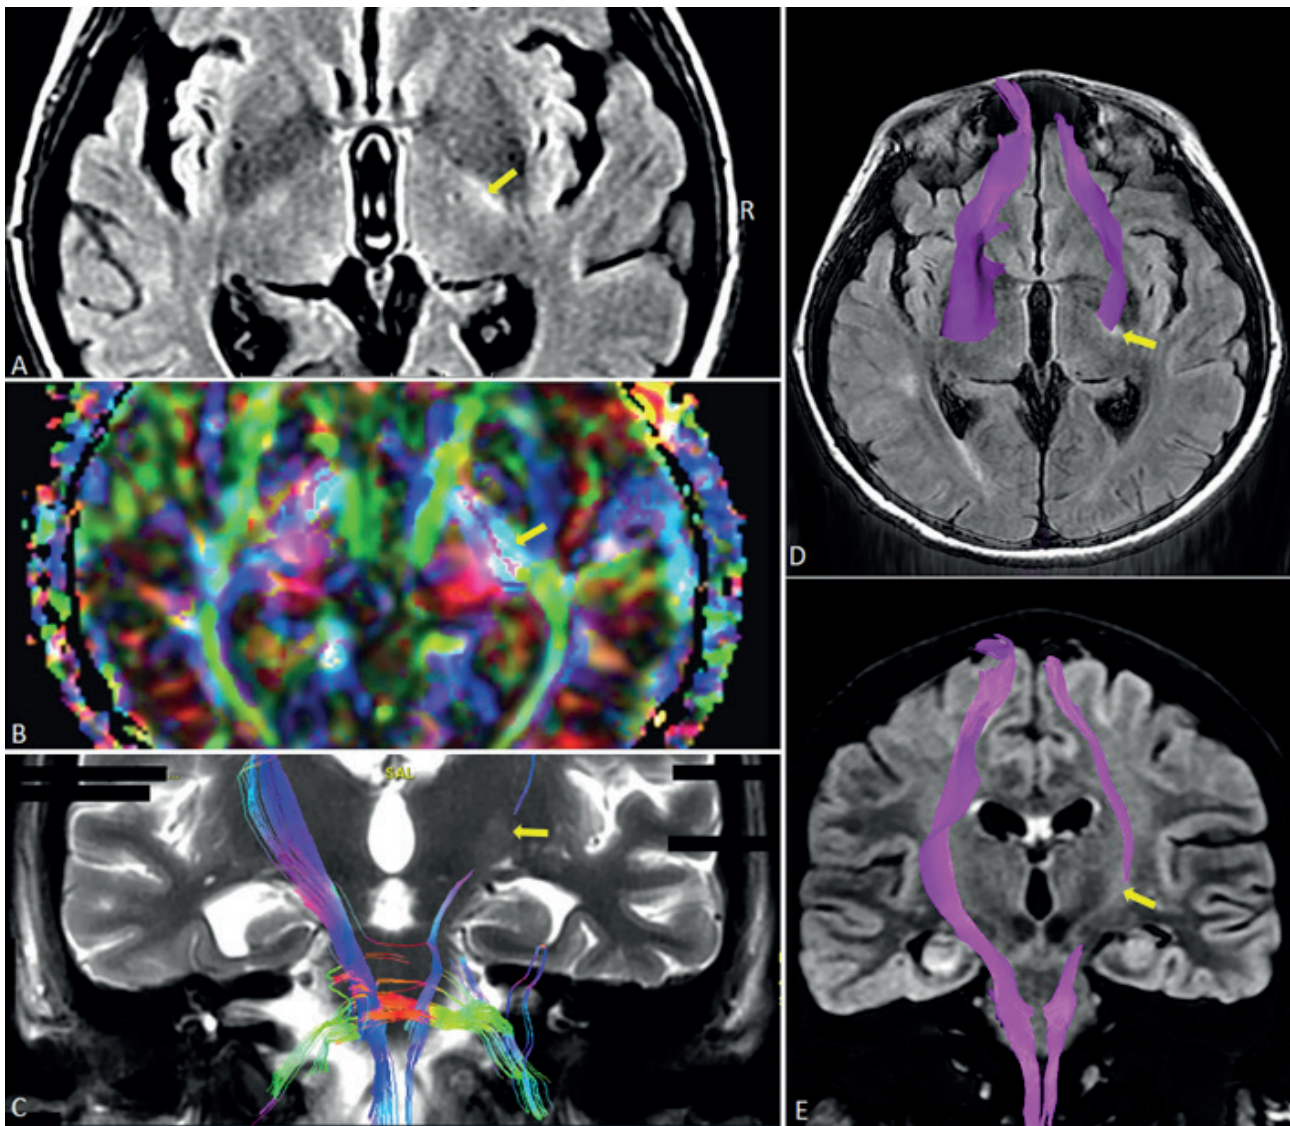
Diffusion tensor imaging (DTI) and tractography magnetic resonance imaging (MRI) findings of diffuse axonal injury
